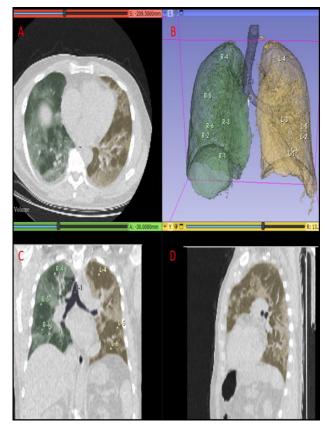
Both lung parenchyma segmentation and 3D volume. A: Axial CT scan section of the lungs showing two regions with green and brown tones. B: 3D reconstruction of the lungs with color-coded segmentation. C: Coronal CT scan section of the lungs showing two regions with green and brown tones and also showing the markups. D: Sagittal CT scan section of the lungs showing two regions with green and brown tones.
